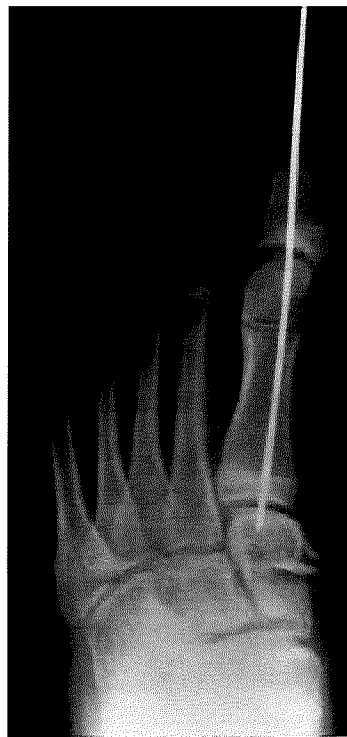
A: Preoperative radiograph of juvenile hallux valgus. *IMA*, intermetatarsal angle. (From Mosca VS. Ankle and foot: pediatric aspects. In: Beaty J, ed. *Orthopaedic Knowledge Update 6*. Rosemont, IL: American Academy of Orthopaedic Surgeons, 1999:583, with permission.) B: Radiograph after medial cuneiform opening-wedge osteotomy and distal first metatarsal closing-wedge osteotomy. (From the private collection of Vincent S. Mosca, MD.)
